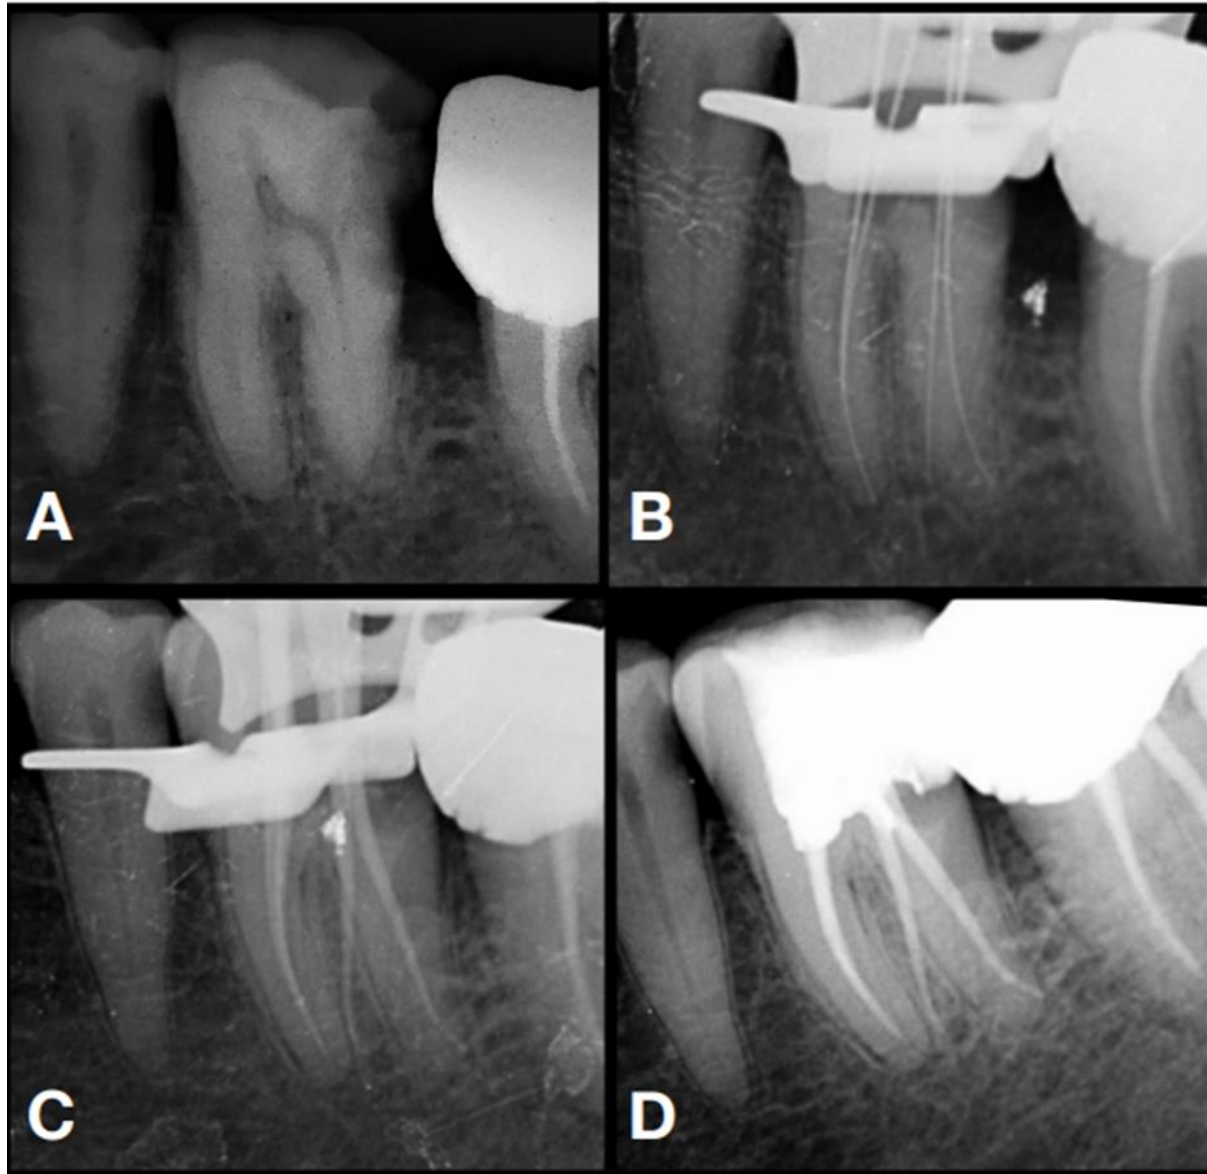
A - Preoperative radiograph , B - Working Length , C - Master cone, D- Obturation
